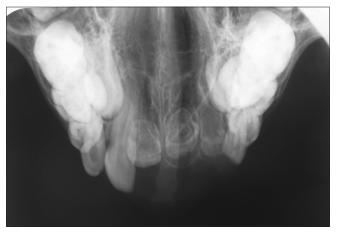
Maxillary anterior occlusal radiograph showing the ghost teeth
